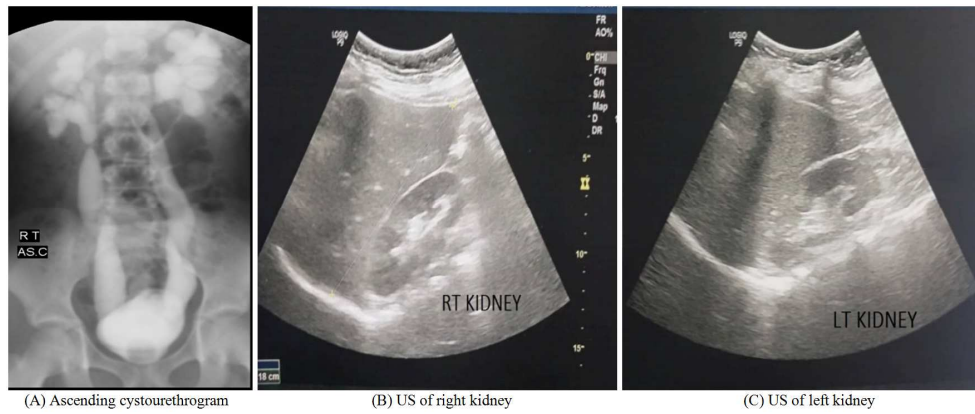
Showed bilateral renal grade (V) VUR (A), fullness of both renal collecting systems (B & C), decreased non-homogenous radioactive tracer uptake in the kidneys with bilateral upper polar and left mid and lower zone cortical defects (hollow arrows)(D), and no additional photopenic areas noted in the SPECT views (E).
